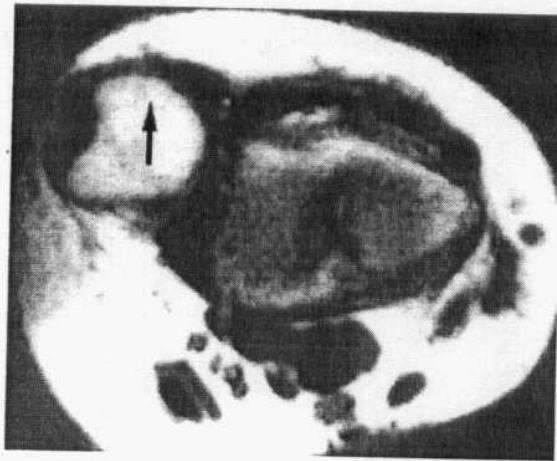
T1-weighted axial image shows dorsal displacement of the ulna (arrow). The ulnar attachment of the volar radioulnar ligament is not seen(Quoted from Stark and Bradly, 1999).
